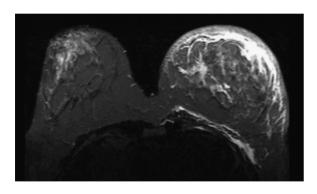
MRI of a 44-year old woman with left inflammatory breast cancer, showing extensive skin thickening.
